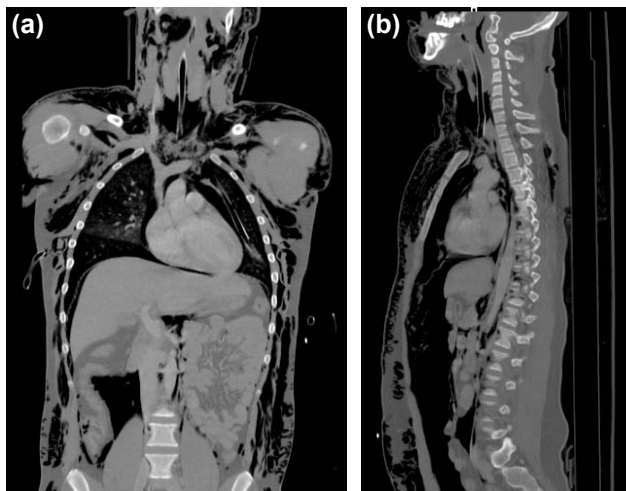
(a) Computed tomography scan showing tracheal detachment at clavicle level. Note extensive subcutaneous emphysema. (b) Computed tomography scan (sagittal view).
